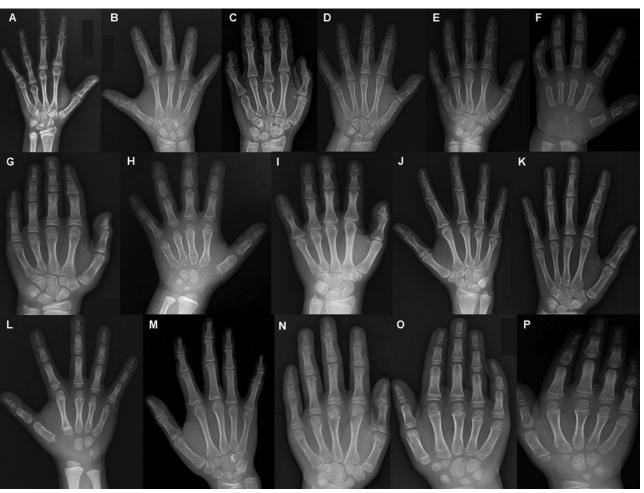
Hand radiographs from patients of the cohort (phalanx shortening and other special features). A, Patient 1: middle phalanx shortening (second and fifth) and severe fourth metacarpal shortening; B, Patient 2: Middle phalanx shortening (all, more second and fifth), distal phalanx shortening (fourth), mild fourth metacarpal shortening, mild first proximal phalanx shortening; C, Patient 3: Middle phalanx shortening (second, fifth, and mild fourth), fifth and third metacarpal shortening, distal phalanx shortening (third); D, Patient 4: Middle phalanx shortening (second and fifth) and distal phalanx shortening (first and third); E, Patient 5: Middle phalanx shortening (second and fifth), distal phalanx shortening (mild first, second, third, and fourth), fifth metacarpal short and wide; F, Patient 6: Clinodactyly (fifth); G, Patient 7: Middle phalanx shortening (second and fifth), distal phalanx shortening (first, third with premature physeal closure in third) cone-shaped epiphyses (third, fourth, and fifth); H, Patient 8: Short hands, broad and short first metacarpal, broad fifth metacarpal; I, Patient 9: Middle phalanx shortening (fifth), distal phalanx shortening (first, second, third, and fifth); J, Patient 10: No abnormal findings; K, Patient 11: Middle phalanx shortening (fifth mild), irregular metaphyses of middle and proximal phalanges (second, third, fourth, and fifth) with cone-shaped epiphyses of middle phalanx shortening (second and fifth); O, Patient 15: Middle phalanx shortening (fifth and mild second) and clinodactyly (fifth); and P, Patient 16: Middle phalanx shortening (second and fifth).
